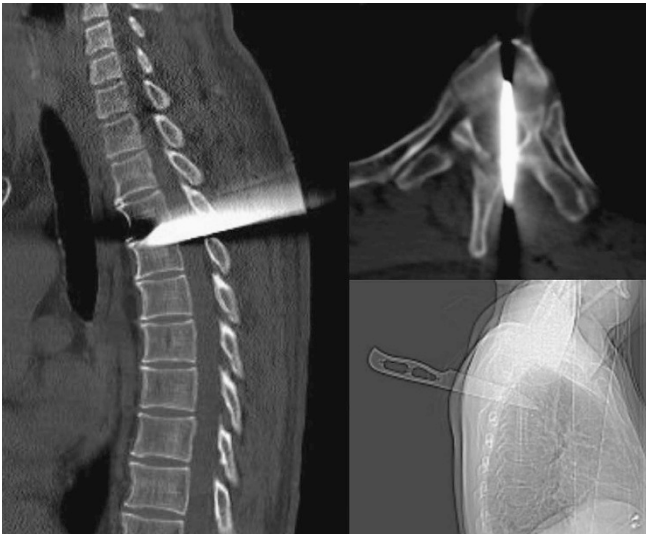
CT of the spine showing 9 cm of the blade tip traversing the spinal canal and reaching the anterior parts of T3 and T4 vertebral bodies.
